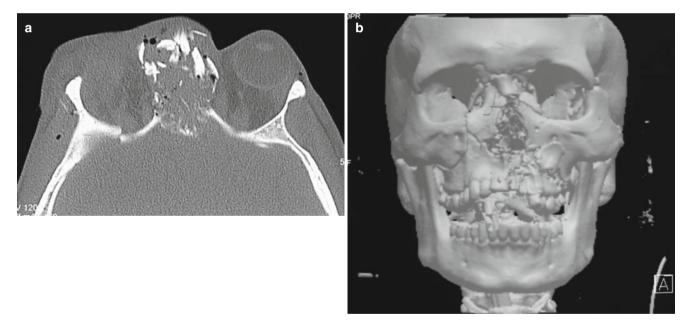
CT clearly shows the highly comminuted nature of this injury, which extends into both orbits and maxillae (a). The left zygoma was also fractured. The frontal sinus/skull base were not significantly injured (b)
